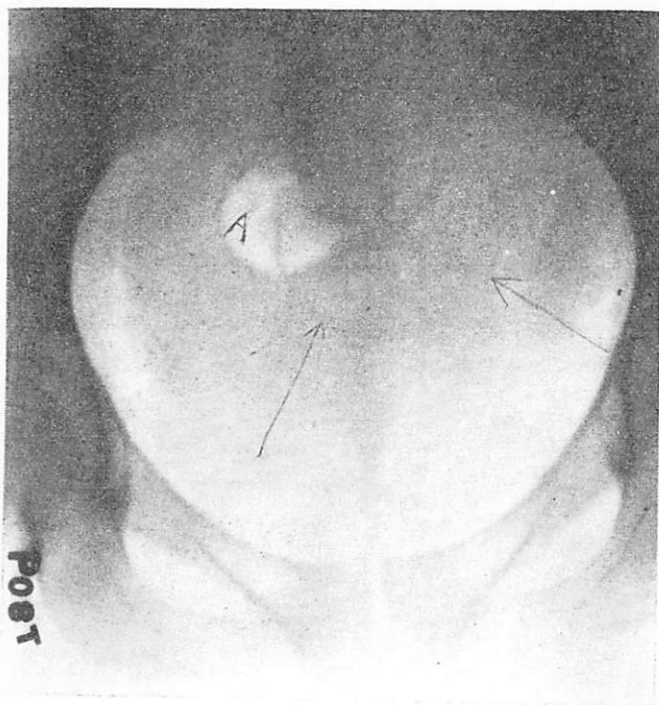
Mrs. M. S., No. 69027. Question of pregnancy associated with fibroids of uterus. A calcified fibroid. Roentgenogram also revealed early pregnancy (sixteen to eighteen weeks).
